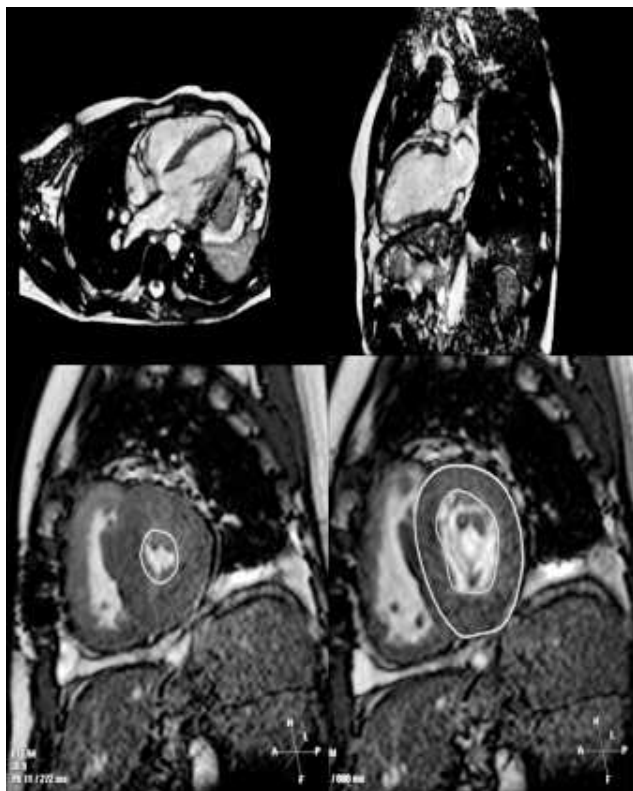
Case: 72-year-old cachectic male with chronic obstructive pulmonary disease and shortness of breath. Echocardiogram was nondiagnostic secondary to poor acoustic window. Cardiac magnetic resonance imaging: Cine images created by steady state free precession. Diagnosis: Ejection fraction, 67.4%; stroke volume of 95.2 cc; end diastolic volume of 141.1 cc; end systolic volume, 45.9 cc; left ventricular mass, 196 g.
